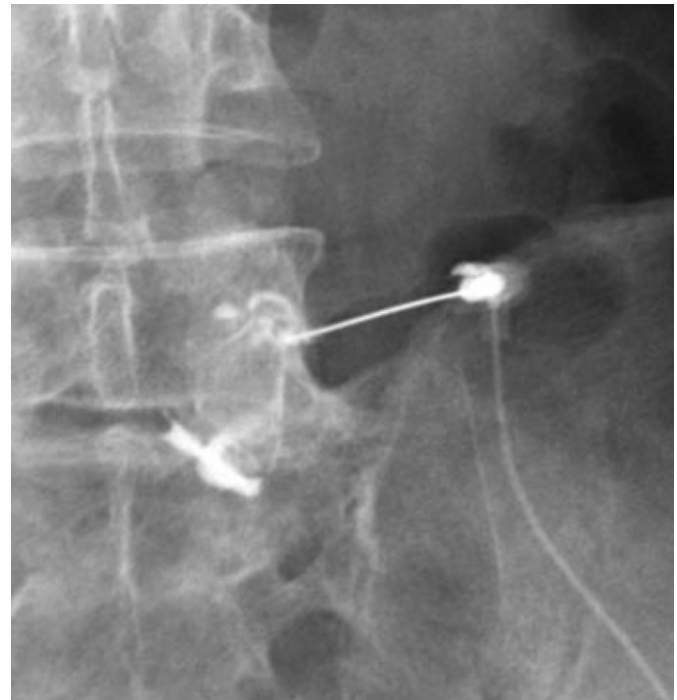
The patient had persistent right lower back and buttock pain. MRI showed L5-S1 facet arthropathy without substantial disk disease. The fluoroscopy image shows the needle placed in the right L5-S1 facet joint with contrast material outlining the joint capsule. The anesthetic agent decreased symptoms immediately, providing diagnostic information about the L5-S1 facet. Medial branch block was subsequently performed.
